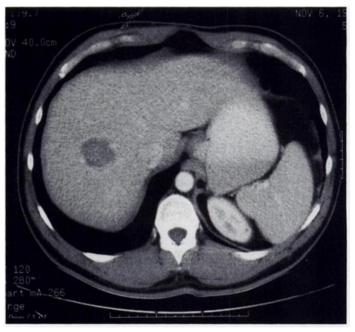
Axial contrast-enhanced CT image of the liver shows a 3-cm low-attenuation lesion due to metastasis in the right hepatic lobe. Multiple smaller lesions were seen in other regions of the liver (not shown).
